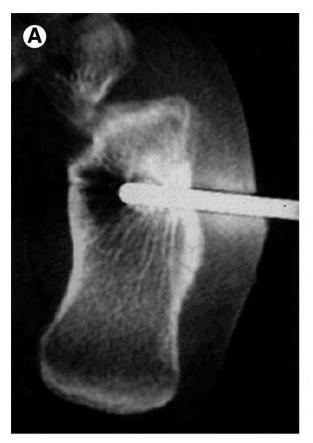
(A) A bone-biopsy needle was percutaneously introduced into the lesion under CT guidance. (B) CT scan showing the channel created by the needle. (C) The RF electrode in the center of the nidus.
